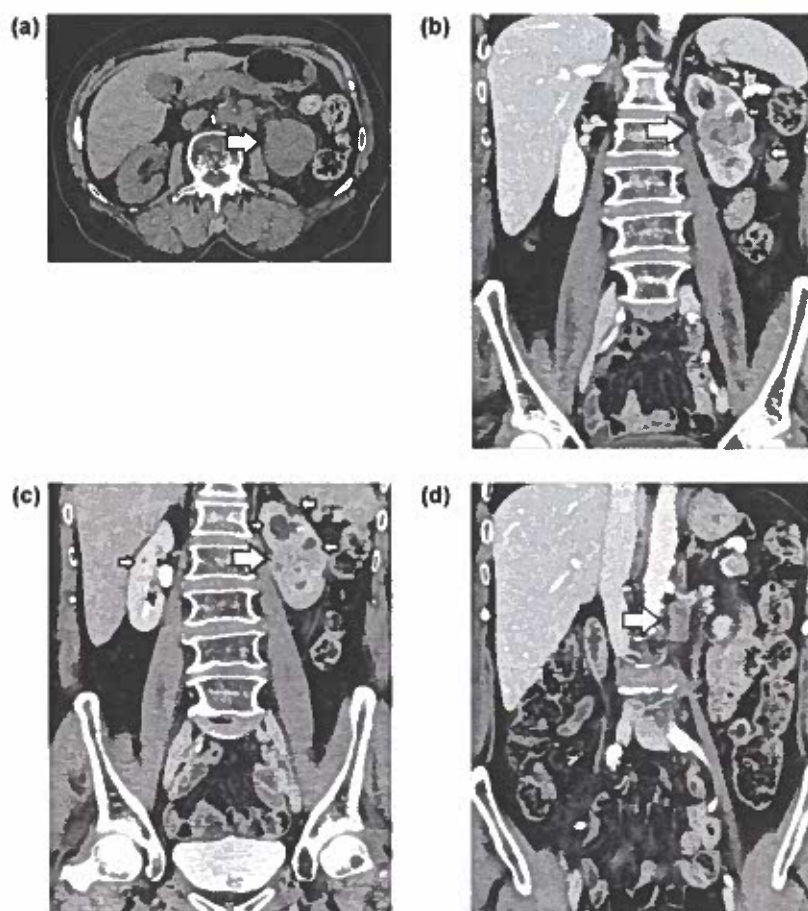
Upper tract urothelial tumor with metastatic retroperitoneal lymphadenopathy. (a) Transverse non-enhanced CT image shows heterogeneous left renal mass (arrow) with obliteration of the renal sinus. Left perinephric stranding is also seen. Coronal reformat images during the (b) nephrographic and the (c) excretory phase depict urothelial malignancy (arrow) inhomogeneously enhancing and invading the pelvicalyceal system. Note, the absence of renal contour deformity by the tumor. (d) Coronal reformation during the nephrographic phases demonstrates enlarged, heterogeneously enhancing left paraaortic lymph nodes (arrow). Small bilateral simple renal cysts (Bosniak classification, version 2019 class I, small arrows, b, c) are also seen.
